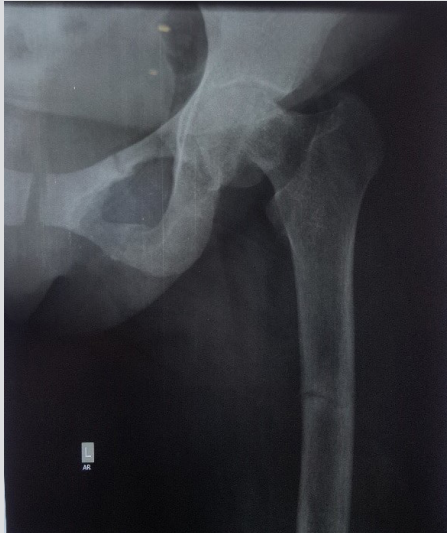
X-ray of the left femur and pelvis, February 2012
